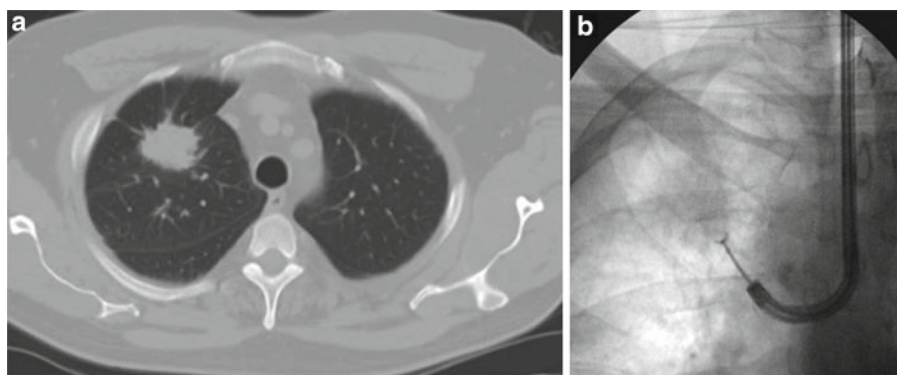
(a) Chest CT showing right upper lobe lung nodule. (b) Biopsy forceps is advanced to the lesion under fluoroscopic guidance to obtain biopsy
